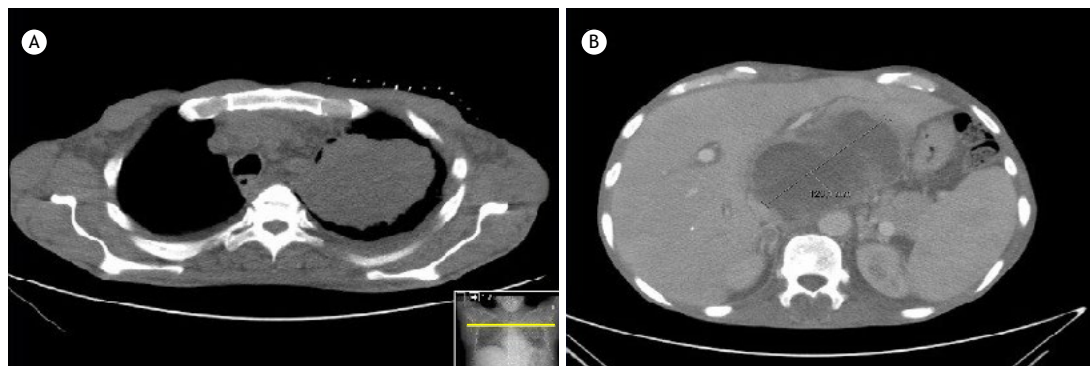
Computed tomography (CT) images. A – Left pulmonary apex with necrotic and abscessed tissue. B – Hepatic abscessed/nodular lesion with necrotic component.
